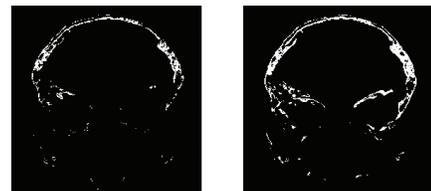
CT and transformed MRI. (a) unregistered, (b) registered. (Bone only.) White regions indicate matched bone regions expressed similarly in the CT and the transformed MRI scan.
